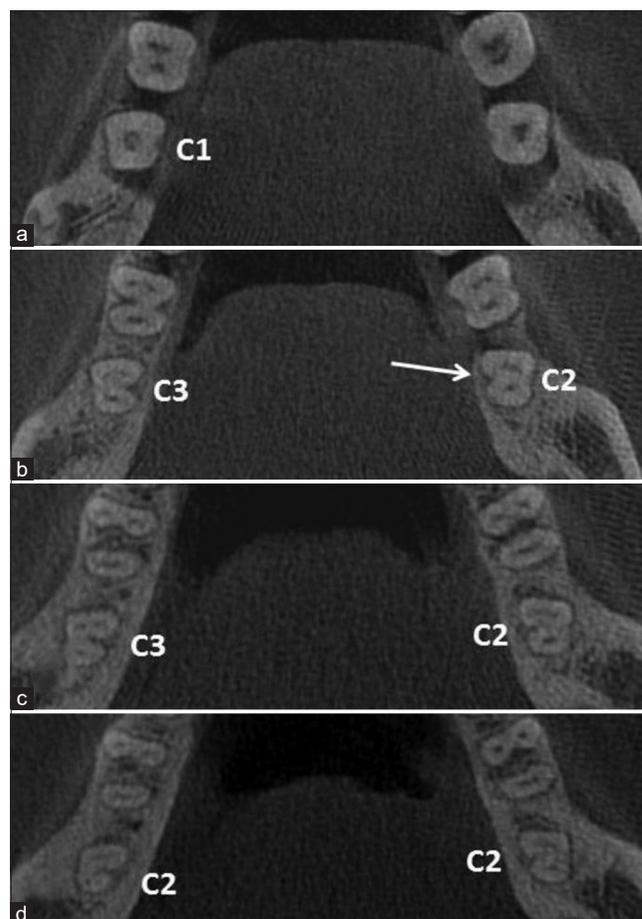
Cone-beam computed tomography axial section of bilateral C-shaped canal of mandibular right and left second molar at different levels with different canal configuration as shown in the canal orifice (a), coronal (b), mid-root (c) and apical (d). Notice the lingual groove with buccal notch of the left molar (arrow)
